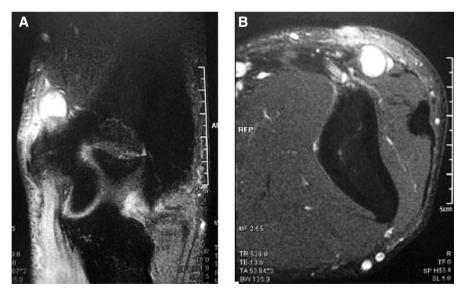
Schwannoma of the ulnar nerve. A T1 weighted MRI images with gadolinium showing homogenous enhancement. B Axial T1 MRI image with gadolinium enhancement
